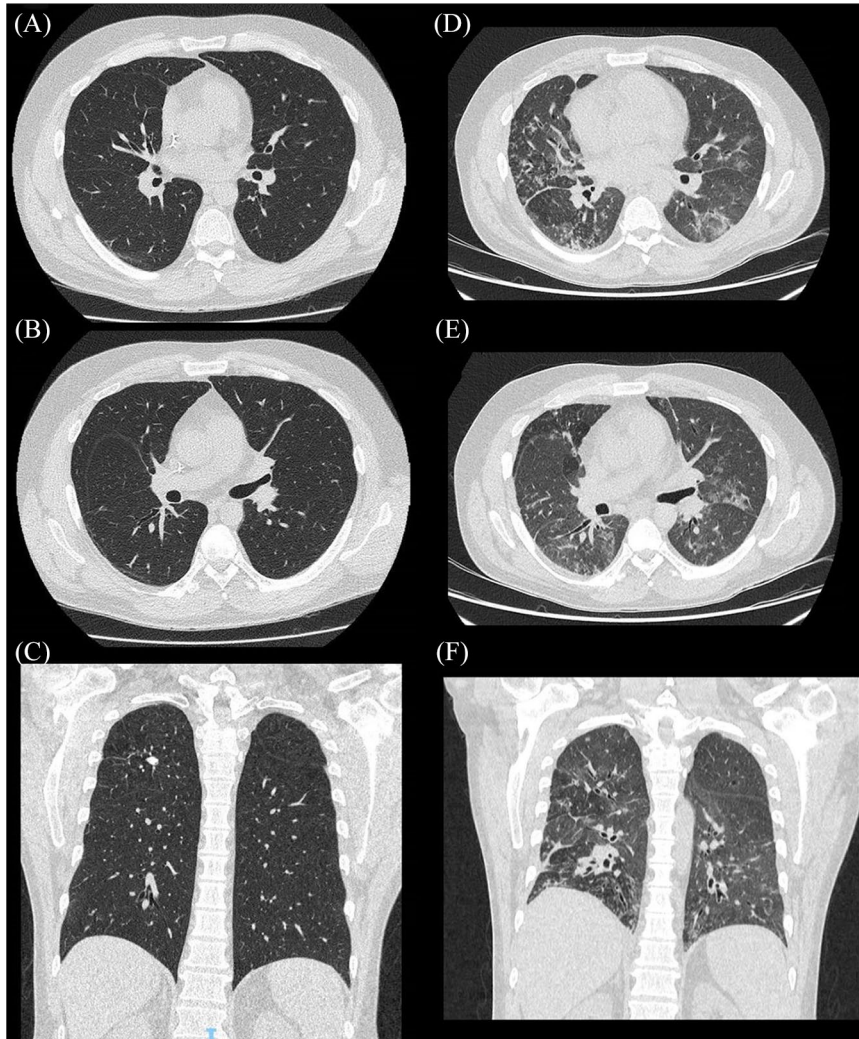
[A–C] HR-CT chest of a 48-year-old man with (DLBCL), prior to infection with COVID-19. [D–F] HR-CT of the same DLBCL patient at the time of diagnosis with COVID-19. Images show bilateral multiple patchy areas of ground-glass changes involving all the lobes, mainly peripheral. Systemic anti-cancer treatment at time of infection was with rituximab and polatuzumab (bendamustine had been held in light of the COVID-19 pandemic). DLBCL, diffuse large B-cell lymphoma; HR-CT, High resolution computed tomography.
